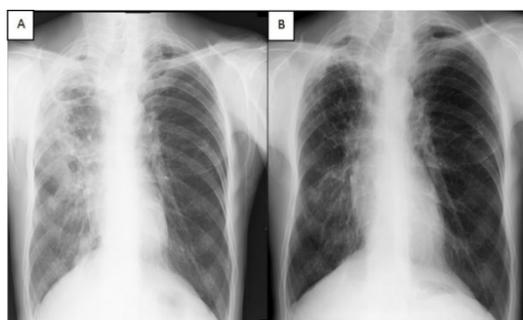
PA Chest X-ray a) before treatment, b) after treatment
